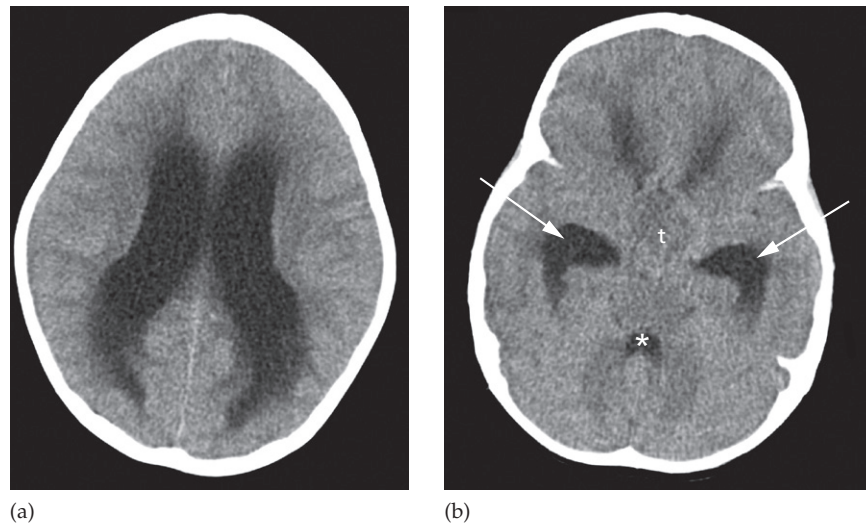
Obstructive hydrocephalus. Axial CT images performed at the level of the lateral ventricles (a) and more inferiorly at the level of the temporal horns (b). The lateral ventricles including the temporal horns (arrows) are dilated but the fourth ventricle (*) is normal in size. The CSF-filled sulci normally seen along the convexities of the cerebral hemispheres are also effaced. The hydrocephalus was due to a tumour (t) obstructing the aqueduct, which connects the third and fourth ventricles.
